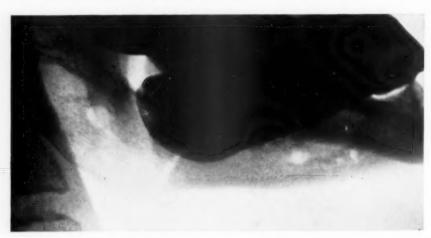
Case 3. X-ray after removal of appliance. The patient wore dentures during the course of treatment.
